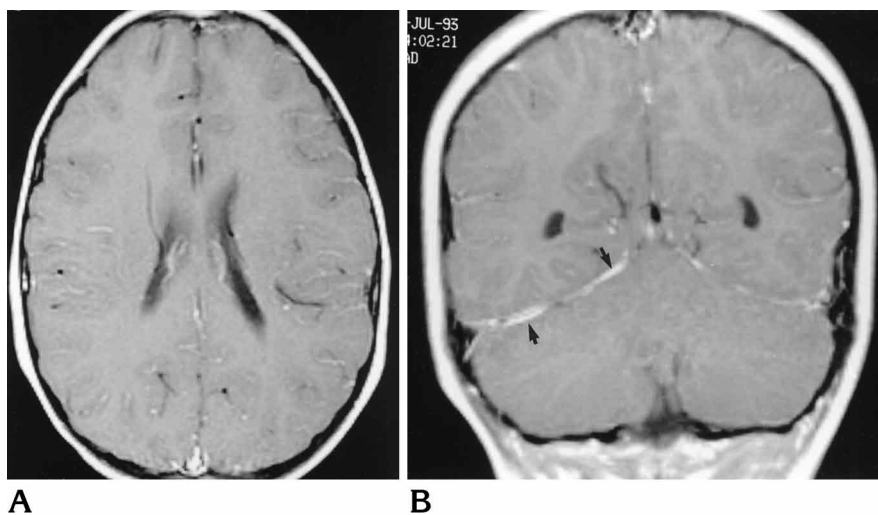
Meningeal enhancement on MR imaging.
